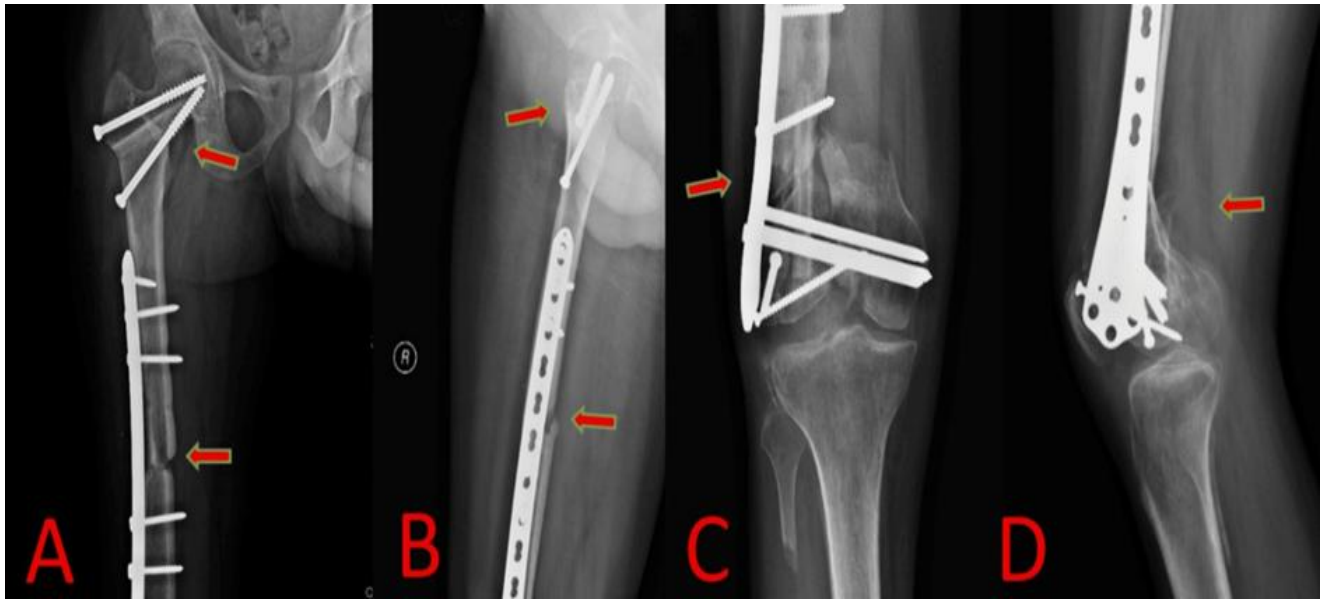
(A-D): Anteroposterior and lateral radiographs of the right femur at two-year follow-up in case 4 showing incomplete union of the distal femur fracture. (A) Anteroposterior radiograph of right proximal femur showing union of right neck and shaft of femur fracture. (B) Lateral radiograph of right proximal femur showing union of right neck and shaft of femur fracture. (C) Anteroposterior radiograph of right distal femur showing incomplete union of the right distal femur fracture. (D) Lateral radiograph of right distal femur showing incomplete union of the right distal femur fracture.
